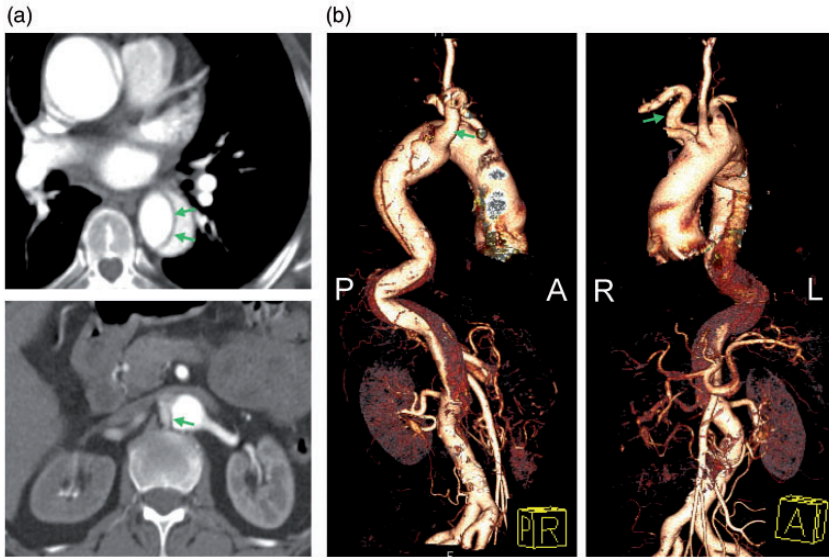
Aortic dissection following attempts to perform right radial angiography in a patient with an aberrant right subclavian artery. (a) Multidetector computed tomography scans showing aortic dissection (arrows, upper panel) with right renal artery involvement (arrows, lower panel). (b) Three-dimensional reconstruction showing the aberrant right subclavian artery (arrows) and the aortic dissection with the poorly perfused right kidney.
